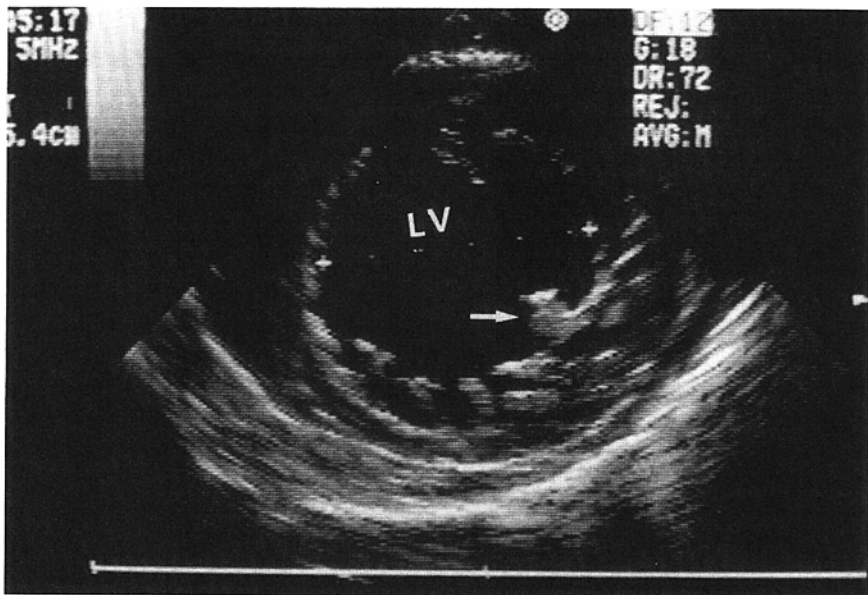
Normal cardiac structures. Transverse, short-axis transesophageal echocardiogram through the left ventricle (LV) demonstrates the ease with which the wall and luminal measurements can be achieved. The origin of a papillary muscle (arrow) is demonstrated. (Courtesy of Dr. Greg Schwartz, Veterans Administration Medical Center, San Francisco, California.)
